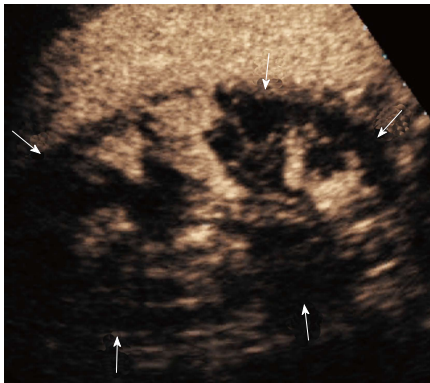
Patient with solitary kidney developing acute renal failure. Contrast enhanced ultrasound showed multiple renal infarctions (arrows) involving a large portion of the parenchyma.
